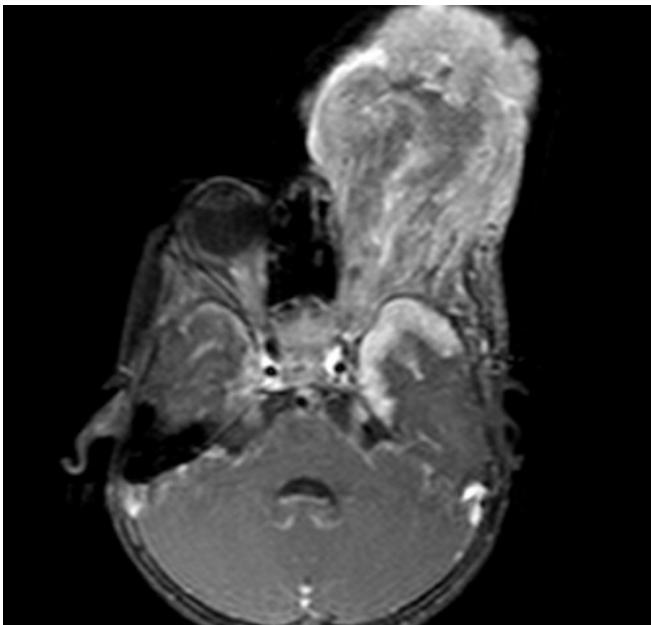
Axial T2-weighted magnetic resonance image showing (a) the extension of the mass into the left optic nerve through the orbital apex into the optic chiasm and (b) a nodular component of the mass occupying the optic chiasm
